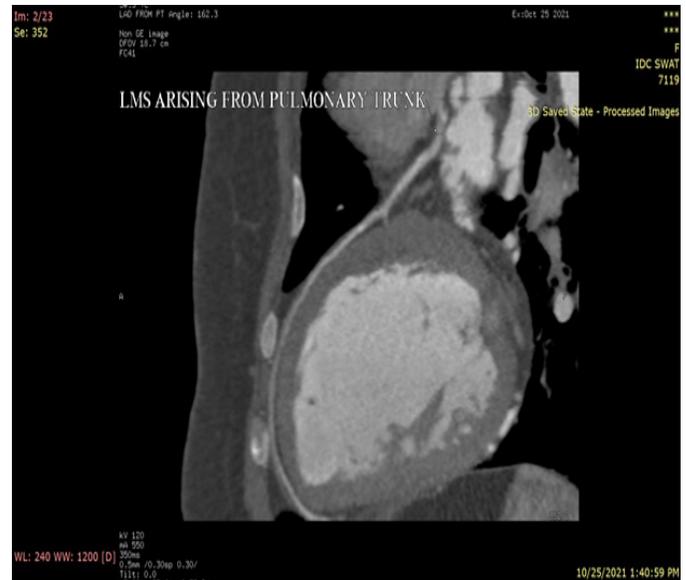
Curved MPR CT coronary angiogram reconstructed image, showing left main stem arising from pulmonary trunk, suggestive of pulmonary artery-derived anomalous left coronary artery (ALCAPA)
